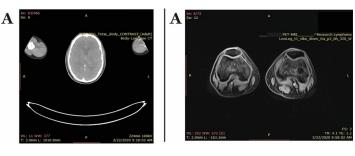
(2020- PET-CT).
